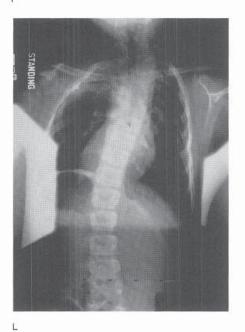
Continued. G and H, Postoperative immobilization in a halo-vest device. Head tilt and rotation were corrected. I, Radiograph obtained 2 years postoperatively showing stabilization of the deformity. J and K, Subsequent clinical appearance. There is no recurrence of the head tilt. L, Radiograph obtained 9 years postoperatively. Correction has been maintained by convex hemifusion anteriorly.
